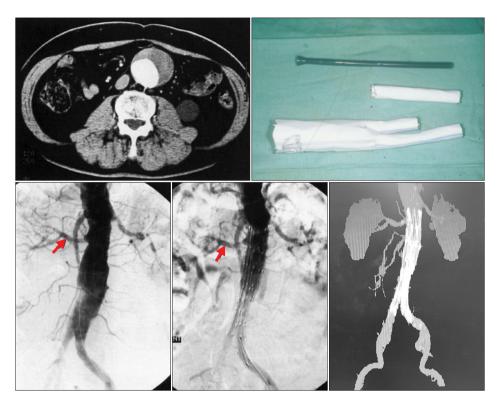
The first fenestrated stentgraft to a renal artery (red arrow) was designed and deployed successfully. Computed tomography after 2 months showed patent right renal artery and excluded aortic aneurysm.
